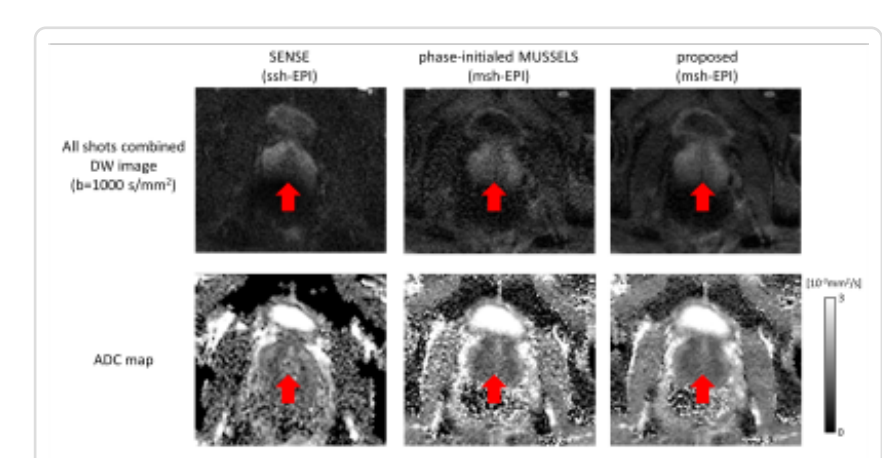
Four diffusion directions combined $b=1000 \text{ s/mm}^2$ prostate DWI (in-plane 1.6 mm) with associated ADC maps, from ssh-EPI and msh-EPI using different reconstructions. Ssh-EPI produced DW images with strong geometric distortions, which can be mitigated by msh-EPI (red arrows). With the same scan time, the MUSSELS result shows lower SNR than ssh-EPI. For the same msh-EPI data, the proposed method can significantly improve the SNR by jointly reconstructing b-values. The same effects can also be seen in the ADC maps.
